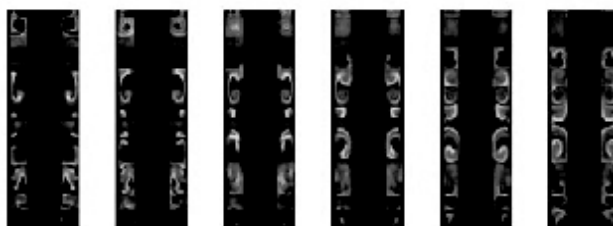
MR images of chemical waves in Taylor-Couette vortices
